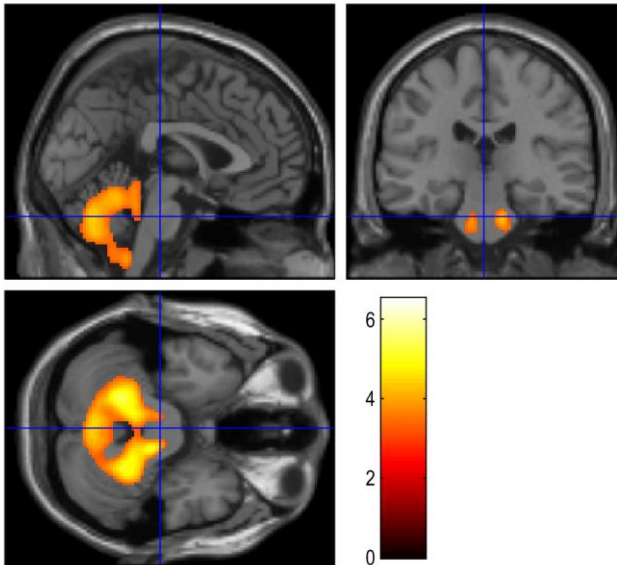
Cluster of relative hypermetabolism of ALS-FTD versus ALS-Cn. The cluster of relative hypermetabolism of ALS-FTD as compared to ALS-Cn is represented on a Magnetic Resonance Imaging template. Upper left box: sagittal section. Upper right box: coronal section. Lower left box: axial section.
